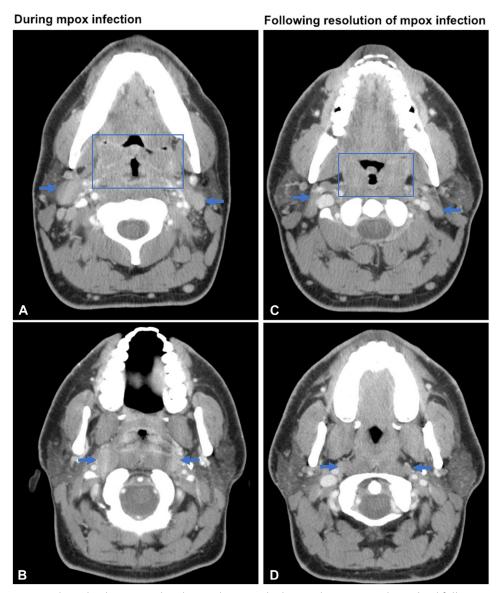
Bilateral palatine tonsil and retropharyngeal adenopathy on CT neck resolved following mpox treatment. A, Bilateral palatine tonsil (box) and level 2 lymph node enlargement (*arrows*) during active mpox infection. B, Bilateral retropharyngeal adenopathy and airway narrowing during active mpox infection. C and D, Reduction in bilateral palatine tonsil enlargement, adenopathy (*arrows*), and airway narrowing 7 months following mpox treatment. *CT*, Computed tomography.
